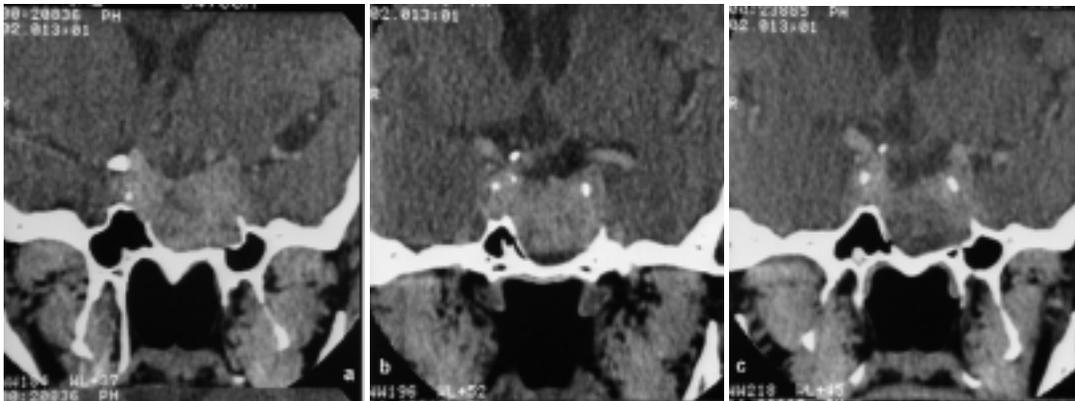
CT scan of a macroprolactinoma before the beginning of DA therapy (a); six months later, after treatment with BRC 30 mg/day- no shrinkage (b); after other 6 months of therapy with BRC 7.5 mg/day - minimal shrinkage (c).
